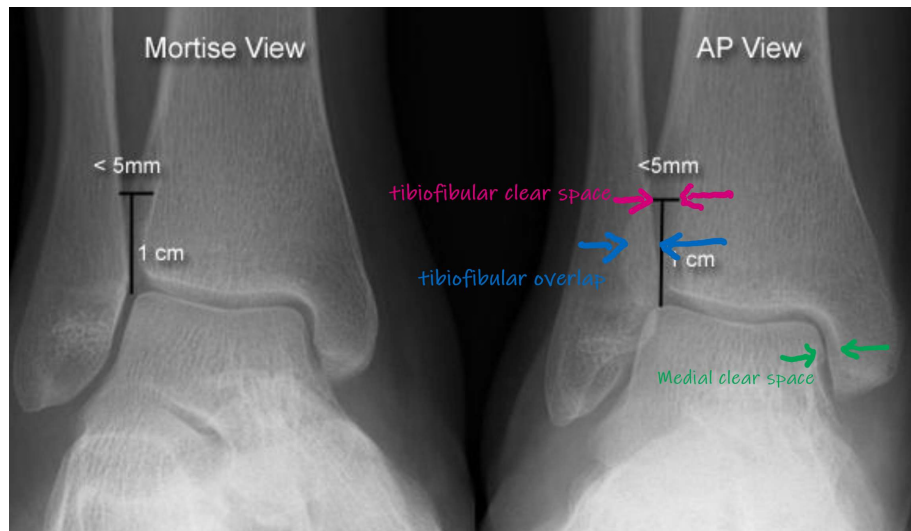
Radiographic features of a normal ankle. Image from Orthobullet and altered to include labels (<https://www.orthobullets.com/foot-and-ankle/7029/high-ankle-sprain-and-syndesmosis-injury>)
